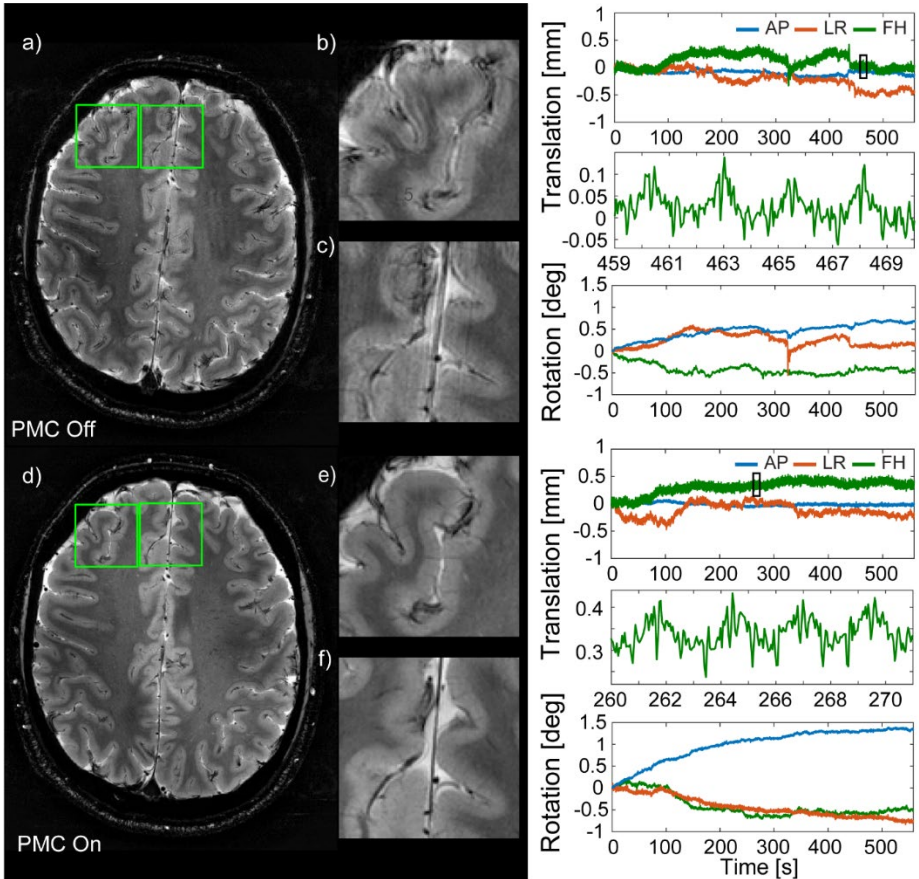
Left: T2-weighted imaging in vivo without deliberate motion. At an in-plane resolution of 0.3 mm even small involuntary head motion notably degrades image quality in the uncorrected case (a-c). With motion correction, image quality is significantly improved (d-f). Right: corresponding motion parameters. Zoomed details of translation in the FH direction reveal minute head motion due to breathing and pulsatile blood flow.*
